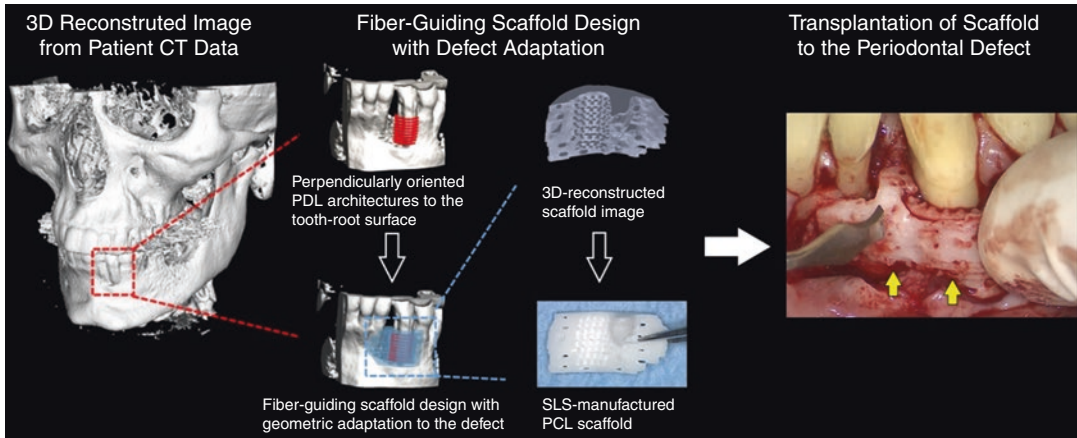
The customized periodontal scaffolding system design and manufacture using CT scanned image dataset and SLS technique for a PCL scaffold. *Modified*
